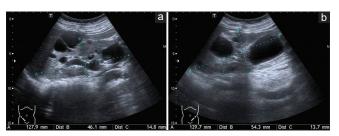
Characteristic ultrasonography (US) presentations of patients carrying *IFT140* mutations. US in a 54-year-old woman shows a few large cysts in the right (a) and left (b) kidneys
